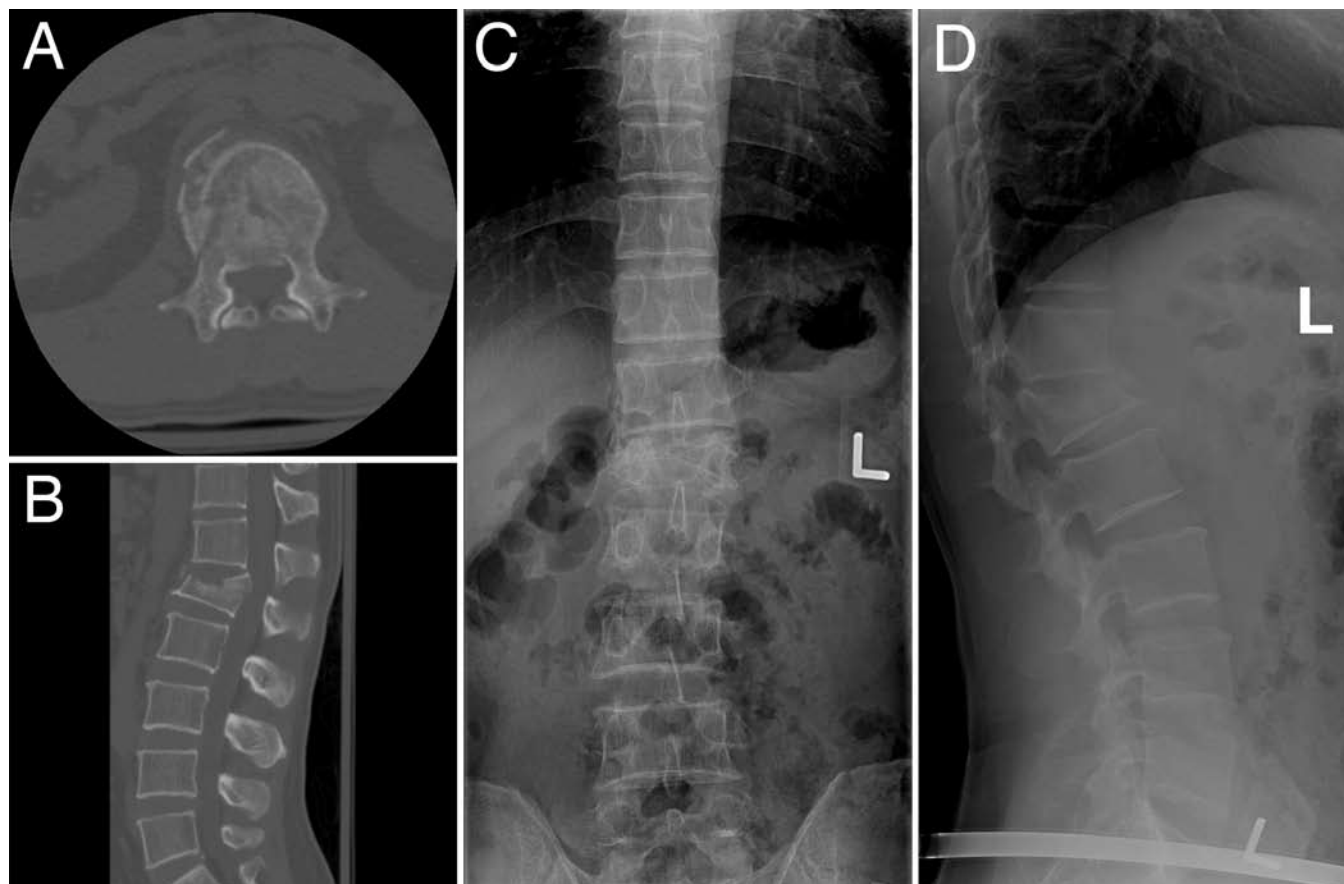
Representative imaging studies in a 42-year-old woman: axial (A) and midsagittal (B) CT scans acquired at the time of injury, and AP (C) and lateral (D) radiographs obtained at 3 months follow-up. At admission, kyphosis was 21° in the supine position and 29° in the standing position at 3 months follow-up.
